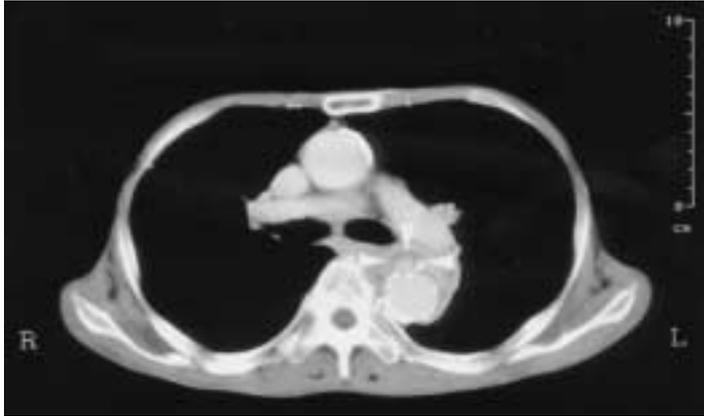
CT scan showing a pseudoaneurysm of the descending aorta.
